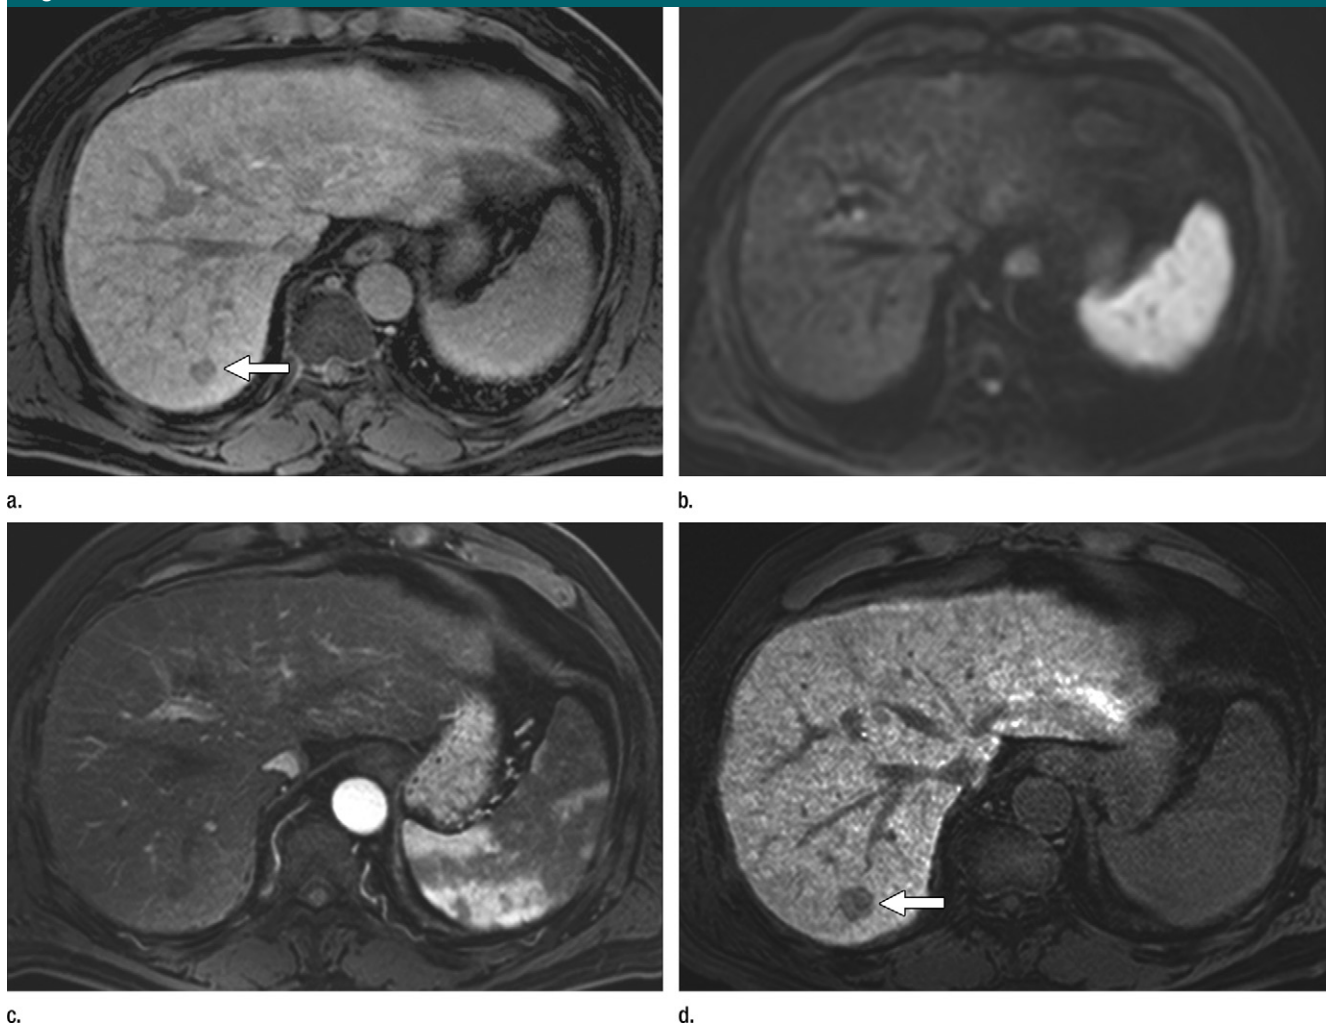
Borderline nodule that did not progress to hypervascular HCC in a 61-year-old man with hepatitis B-induced liver cirrhosis. (a) Axial gadoteric acid-enhanced 20-minute HBP image shows a hypointense nodule (arrow). (b) Axial single-shot echo-planar DW image ($b = 800 \text{ sec/mm}^2$) shows no liver mass. (c, d) Axial gadoteric acid-enhanced MR images obtained 16 months later show no enhancing mass lesion at (c) arterial phase and a hypointense nodule (arrow) with an interval increase in size, compared with that on a, at (d) 20-minute HBP.
